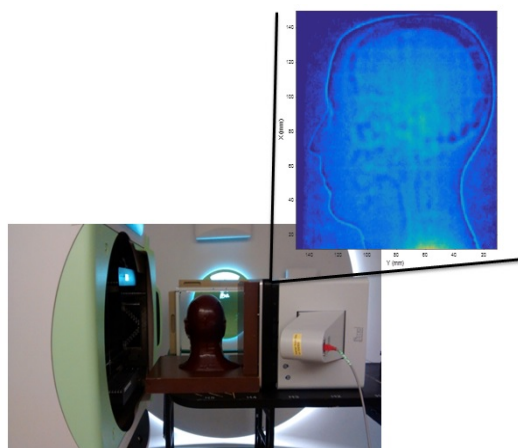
Experimental set-up with an example of proton radiograph imaged at beam energy of 220 MeV.
